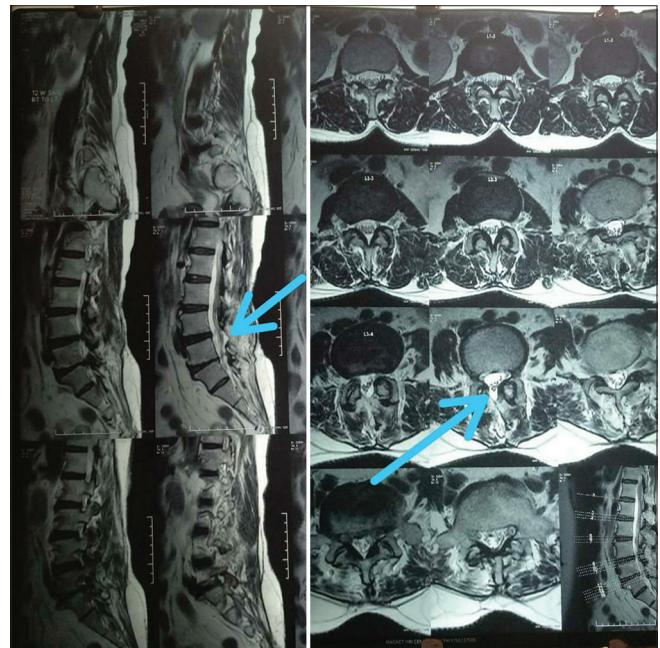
Pre-operative MAGNETIC resonance imaging scan showing pseudomeningocele (blue arrow) at L3-L4 level with disc herniations at L3-L4 and L4-L5 levels and sacralization of L5
